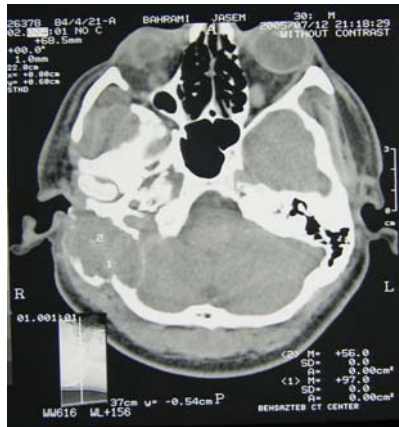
Axial tumor CT scanning.
